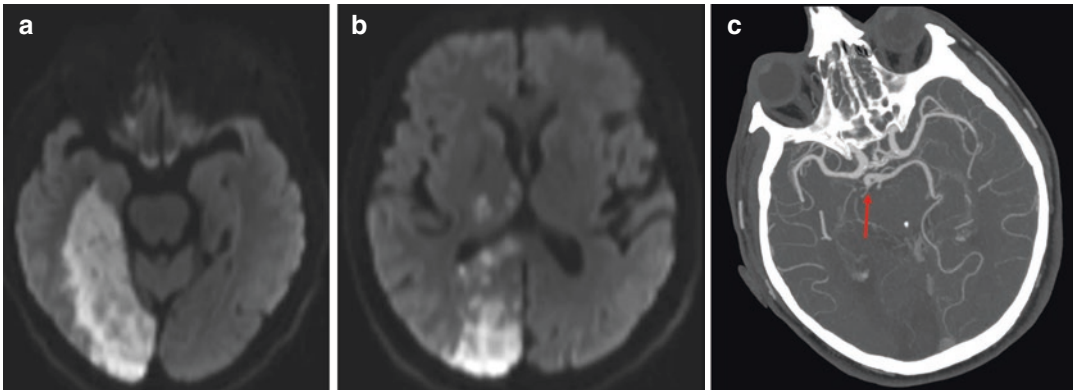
Diffusion-weighted MRI showing a large right PCA infarction involving the temporal lobe (a), the occipital lobe and the median and lateral thalamus (b).
